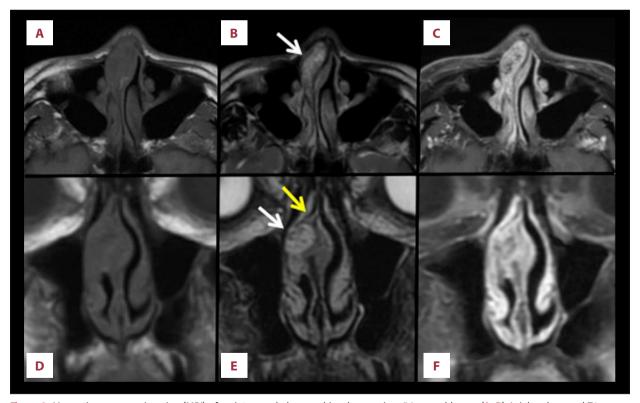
Magnetic resonance imaging (MRI) of an intranasal pleomorphic adenoma in a 56-year-old man. (A, D) Axial and coronal T1-weighted imaging shows a mass with low signal intensity in the right nasal cavity. (B) An axial T2-weighted image shows a tumor with heterogeneous low and slightly high signal intensity. (E) A coronal T2-weighted image shows a structure with low signal intensity that is connected to the nasal septum. The white arrow indicates the tumor, and the yellow arrow indicates the structure with a 'beak sign,' which suggests that it is a submucosal tumor and the attachment site is the nasal septum. (C, F) A contrastenhanced T1-weighted image shows heterogeneous enhancement without tumor infiltration into the surrounding tissues.
